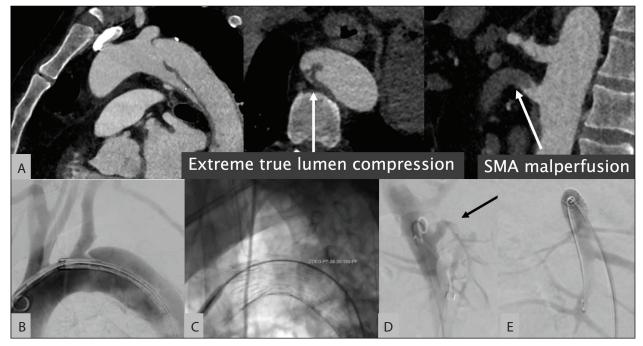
Preoperative CTA showing the large entry tear (left), the extremely compressed TL (middle) and superior mesenteric artery malperfusion (right) (A). Placement of thoracic endograft in Ishimaru zone 2 (B). Deployment of thoracic endograft (C). Diagnostic angiogram showing the superior mesenteric artery malperfusion (D). Control superior mesenteric artery angiogram after stenting (E).
